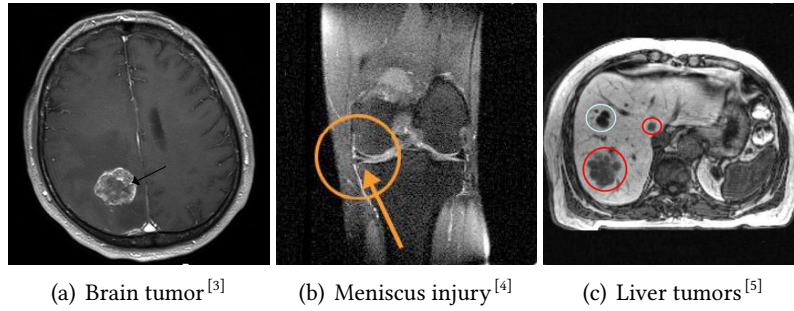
Magnetic Resonance Images from different medical applications: Diagnosis is based on evaluating a magnitude image from a complex-number data set.
